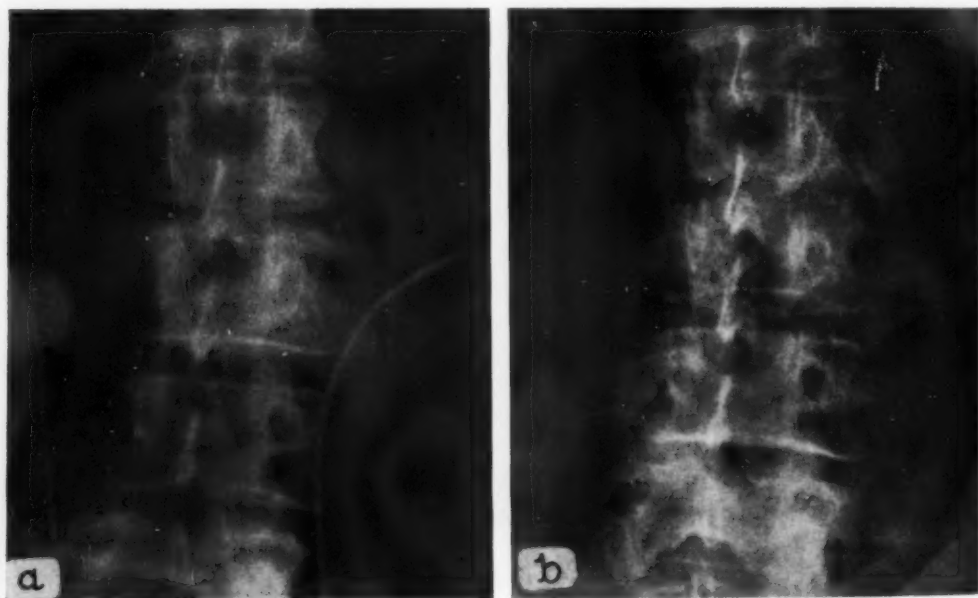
Case IV. a. Detail of a roentgenogram made during cystoscopy on June 8, 1953. No spinal lesion is present. b. The same area on July 14, 1953, after onset of back pain. An inflammatory process is now present at L2-3.
